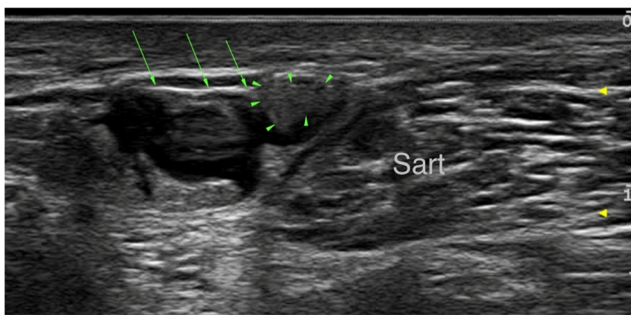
Ultrasound-guided injection showing spreading of the medication (hypochoic fluid) around the lateral femoral cutaneous nerve (LFCN). In-plane needle placement (arrows) from lateral was close to the LFCN (between arrowheads). The inguinal ligament is depicted ventrally as a transverse linear hypochoic stripe. (*Sart*) sartorius muscle
